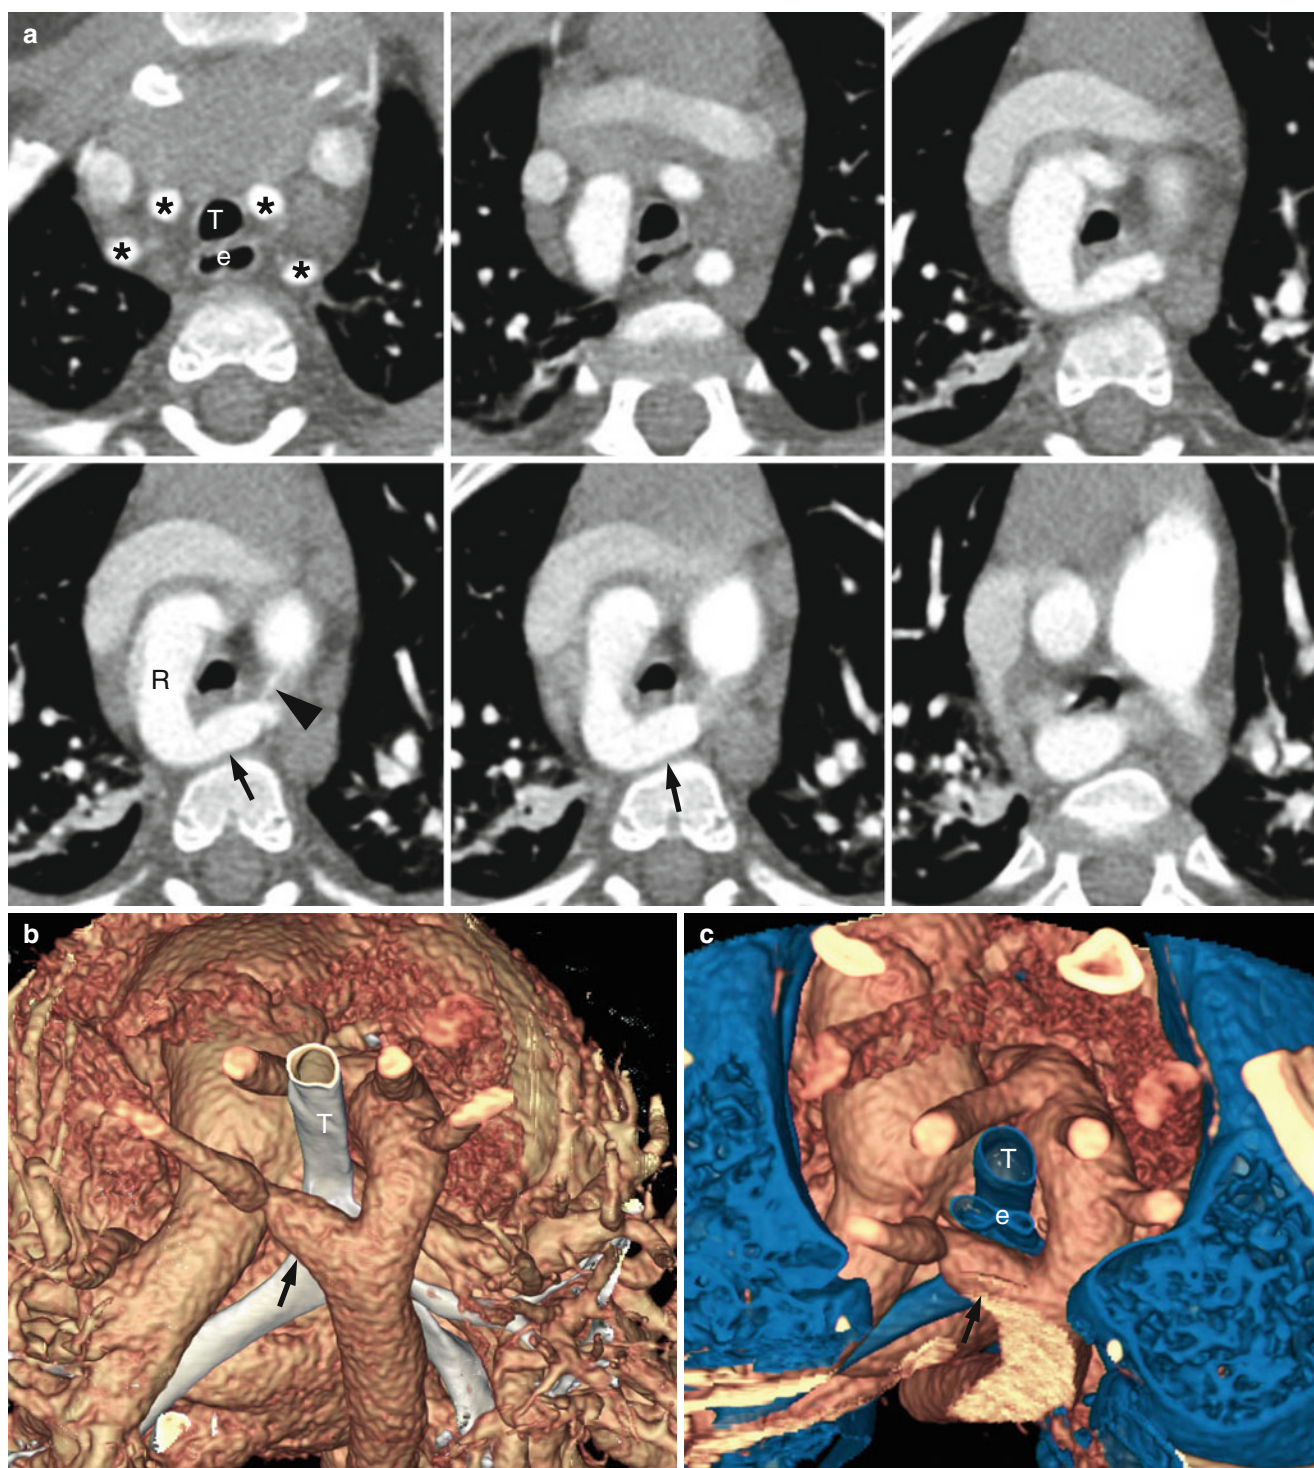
Right aortic arch with an aberrant left subclavian artery and diverticulum of Kommerell in a 2-year-old boy. (a) Axial CT images show an aberrant left subclavian artery arising as the last branch of the right aortic arch (R). There is an aneurysmal dilatation at its origin to form a diverticulum of Kommerell (arrows), and it courses behind the esophagus to reach its normal position. A small PDA (arrowhead) connects the left subclavian artery and pulmonary artery to
